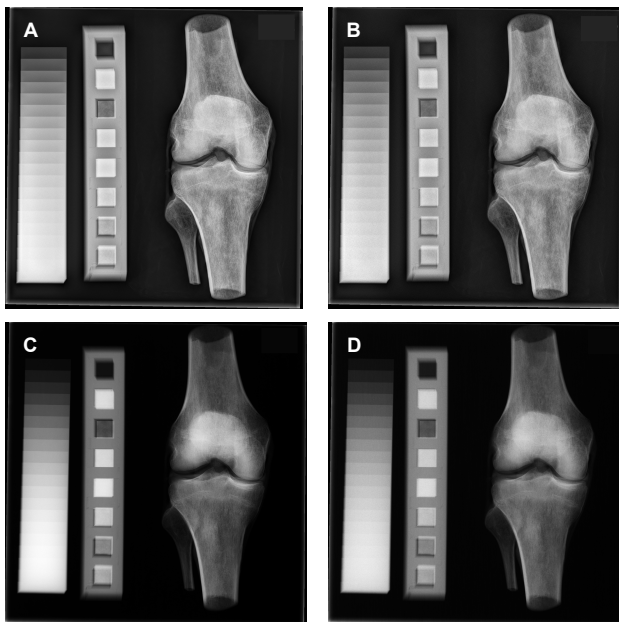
Screenshot of digital radiographs:
